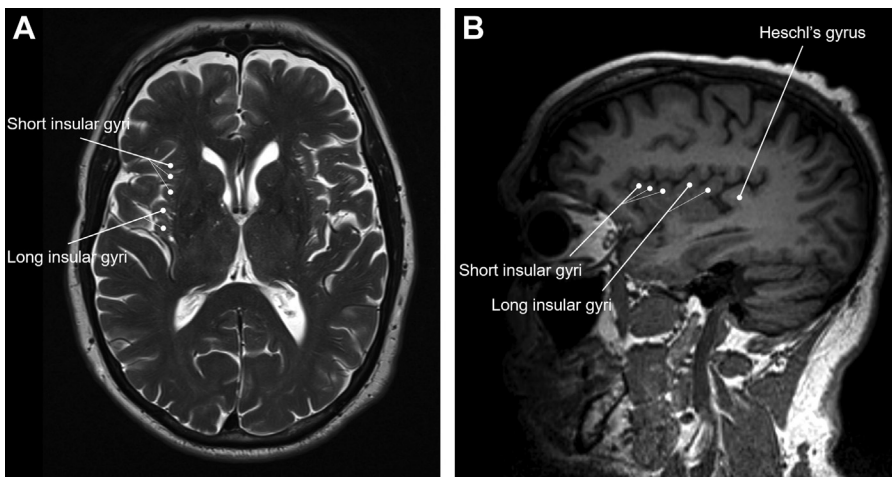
Axial and sagittal images of the insula. (A) Axial T2-weighted spin-echo image demonstrating the division of the insula into the anterior, middle, and posterior short insular gyri anteriorly and the anterior and posterior long insular gyri posteriorly. (B) Sagittal T1-weighted image shows the short and long insular gyri separated by the central sulcus of the insula, and Heschl gyrus posteriorly.
